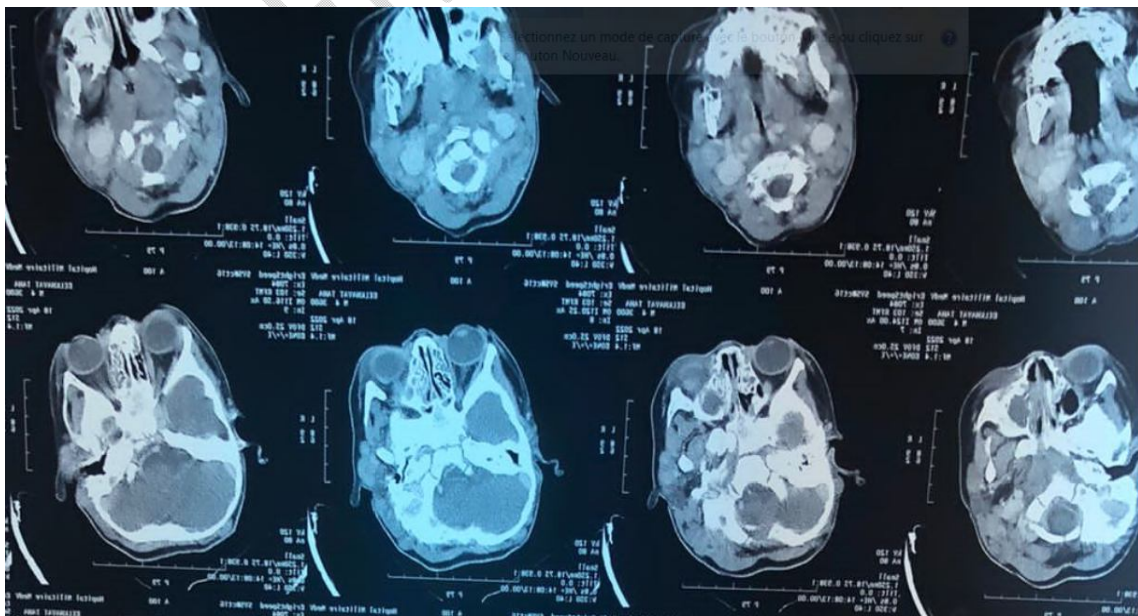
Cerebral-orbital CT scan with contrast injection showing pre-septal orbital cellulitis with sinusitis.
